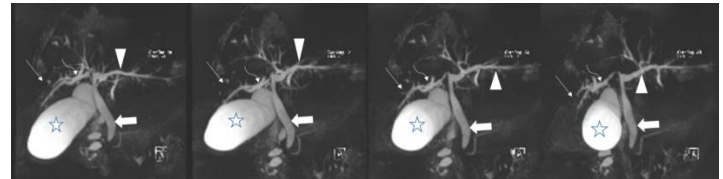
In the magnetic resonance cholangiopancreatography images obtained using the T2-weighted sequence; the gallbladder was observed in hydroptic appearance (star). The choledochus was dilated and the blunt end was distal (arrow). Distal segment of right intrahepatic biliary tract was seemed occluded due to mass compression (thin arrow) and was dilated in the proximal part (curved arrow).
